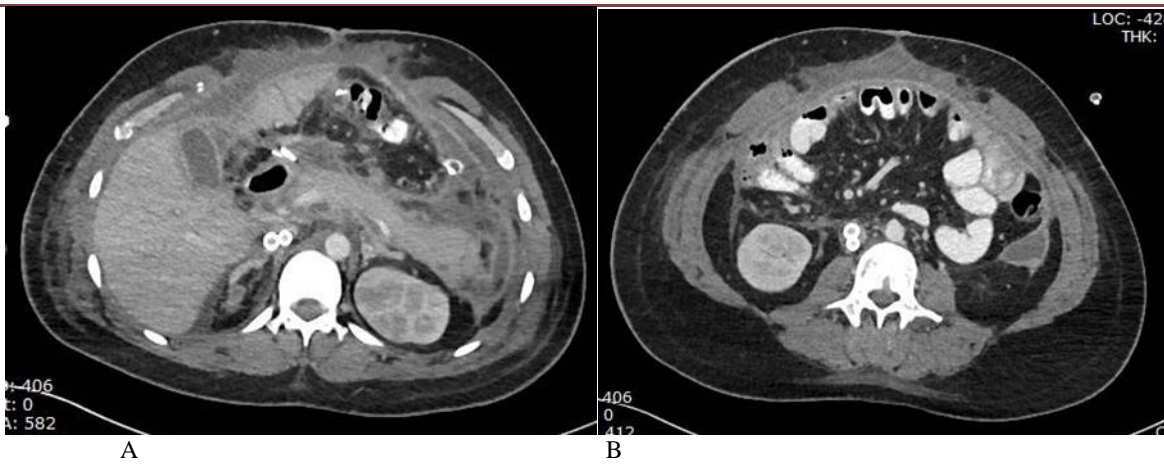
A, B, : Contrast enhanced CT scan 4 weeks later shows reduced perisplenic collection measuring 54.0 ml, perihepatic collection about 30.0 ml, and left para colic collection measures 45.0 ml.
